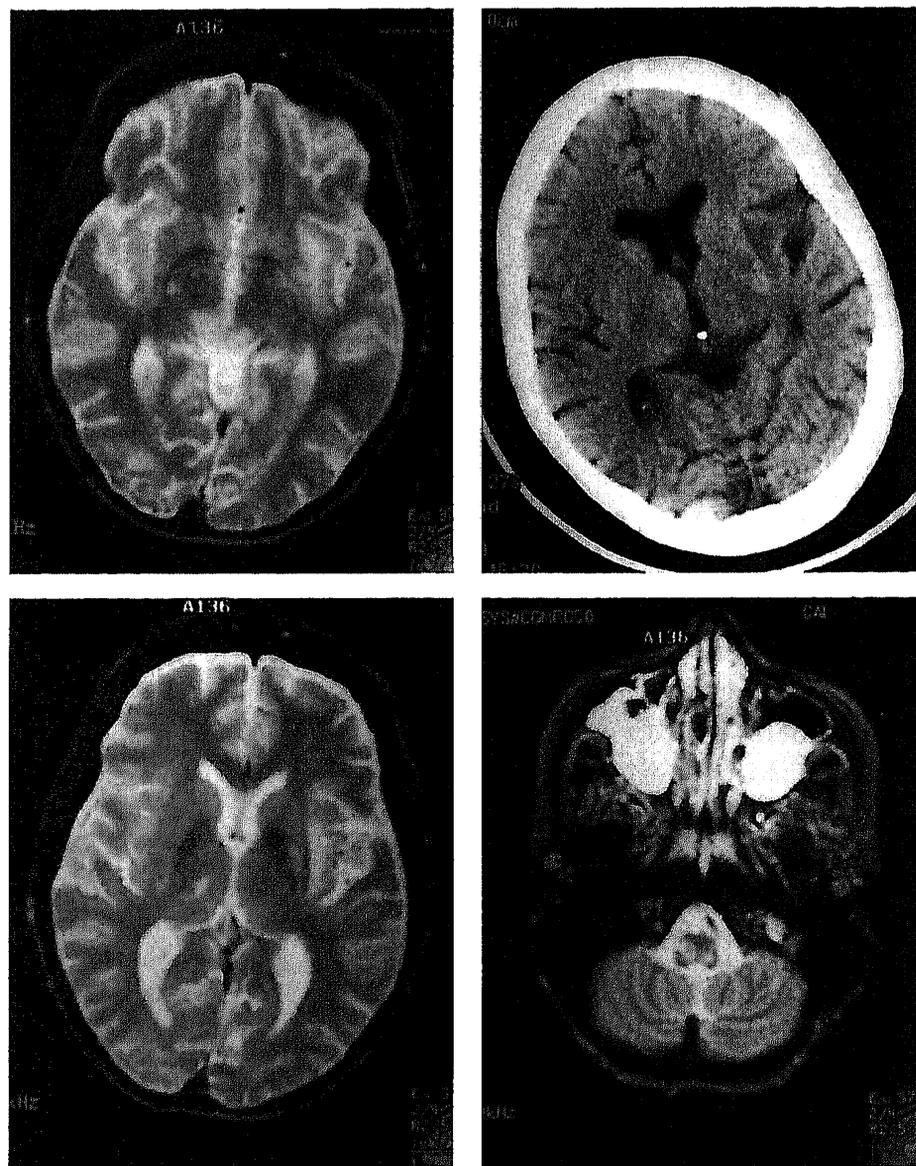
Head CT and MRI scans show multiple areas of demyelination involving the brain stem and paraventricular white matter in a woman with AIDS who developed progressive multifocal leukoencephalopathy.
